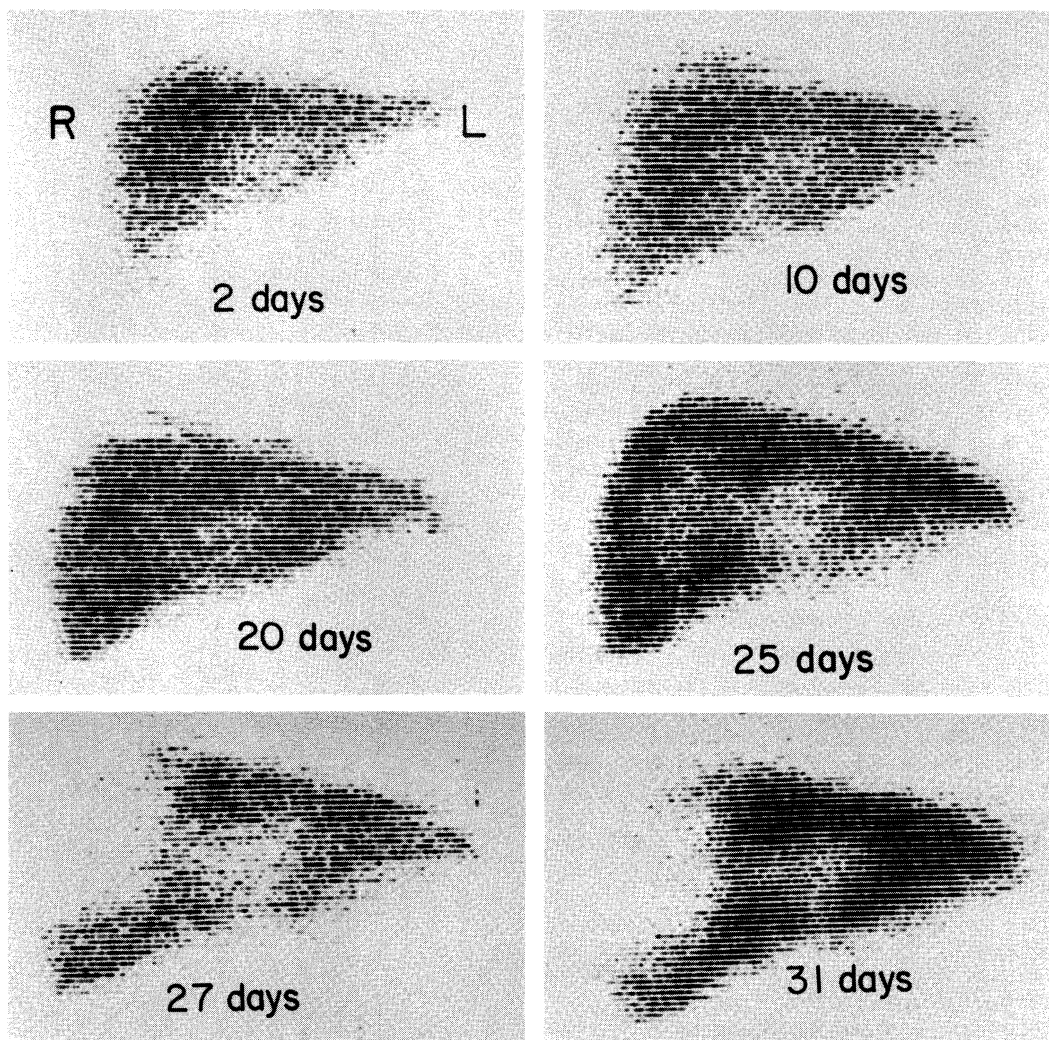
Postoperative technetium scans of the liver in a 13 month old infant whose indication for orthotopic transplantation was biliary atresia. *2 days*: The small homograft is normal. *10 days*: An increase in size is evident although the general configuration of the organ is still normal. *20 days*: No further change is noted. *25 days*: The examination was conducted as an emergency when gram-negative septicemia developed and very high increases in the transaminases appeared. Areas of decreased isotope uptake are obvious in the right lobe and the central part of the liver. *27 days*: A striking extension of the process can be seen less than 48 hours later. A debridement procedure was carried out the same evening. *31 days*: Four days after debridement the radiographic appearance was improved.
